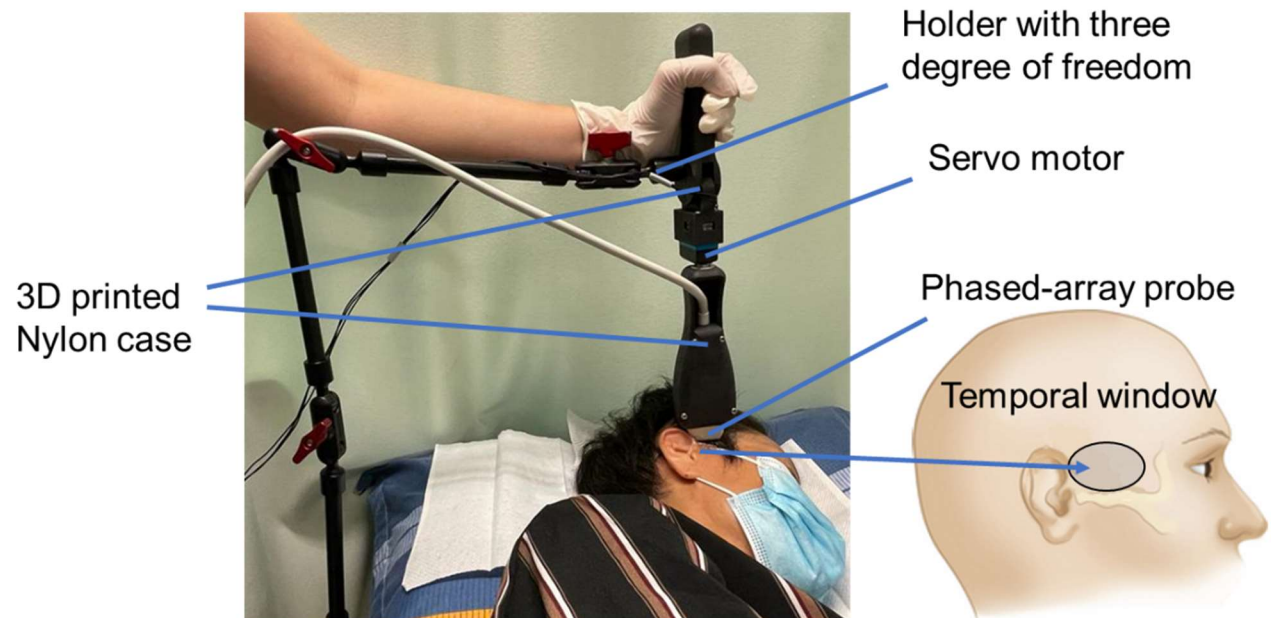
Handheld design and the setup for UBA data acquisition. The 3D printed Nylon case was used to assemble the servo motor and the phased array probe. During the data collection, the phased array probe was attached to the region of the temporal window (gray area). Ultrasound gel was applied to maintain acoustic coupling between the transducer and skin surface. The scanning probe was stabilized using the holder arm to minimize the movement during scanning for imaging.
